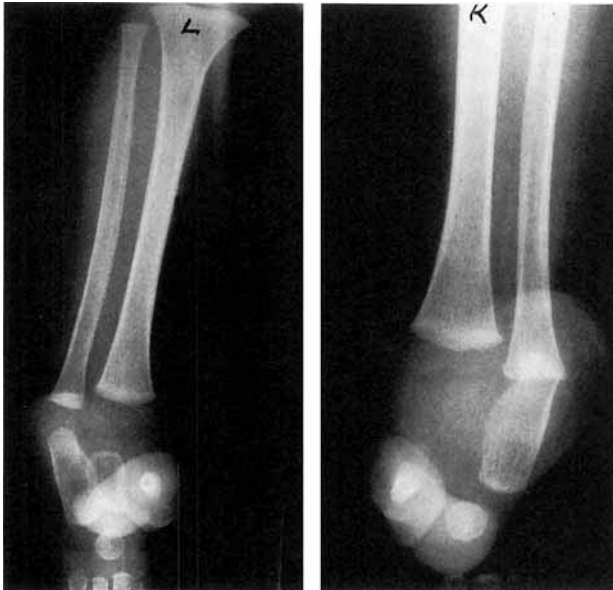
Roentgenogram of legs of patient 1; note short and hypoplastic tibiae.
